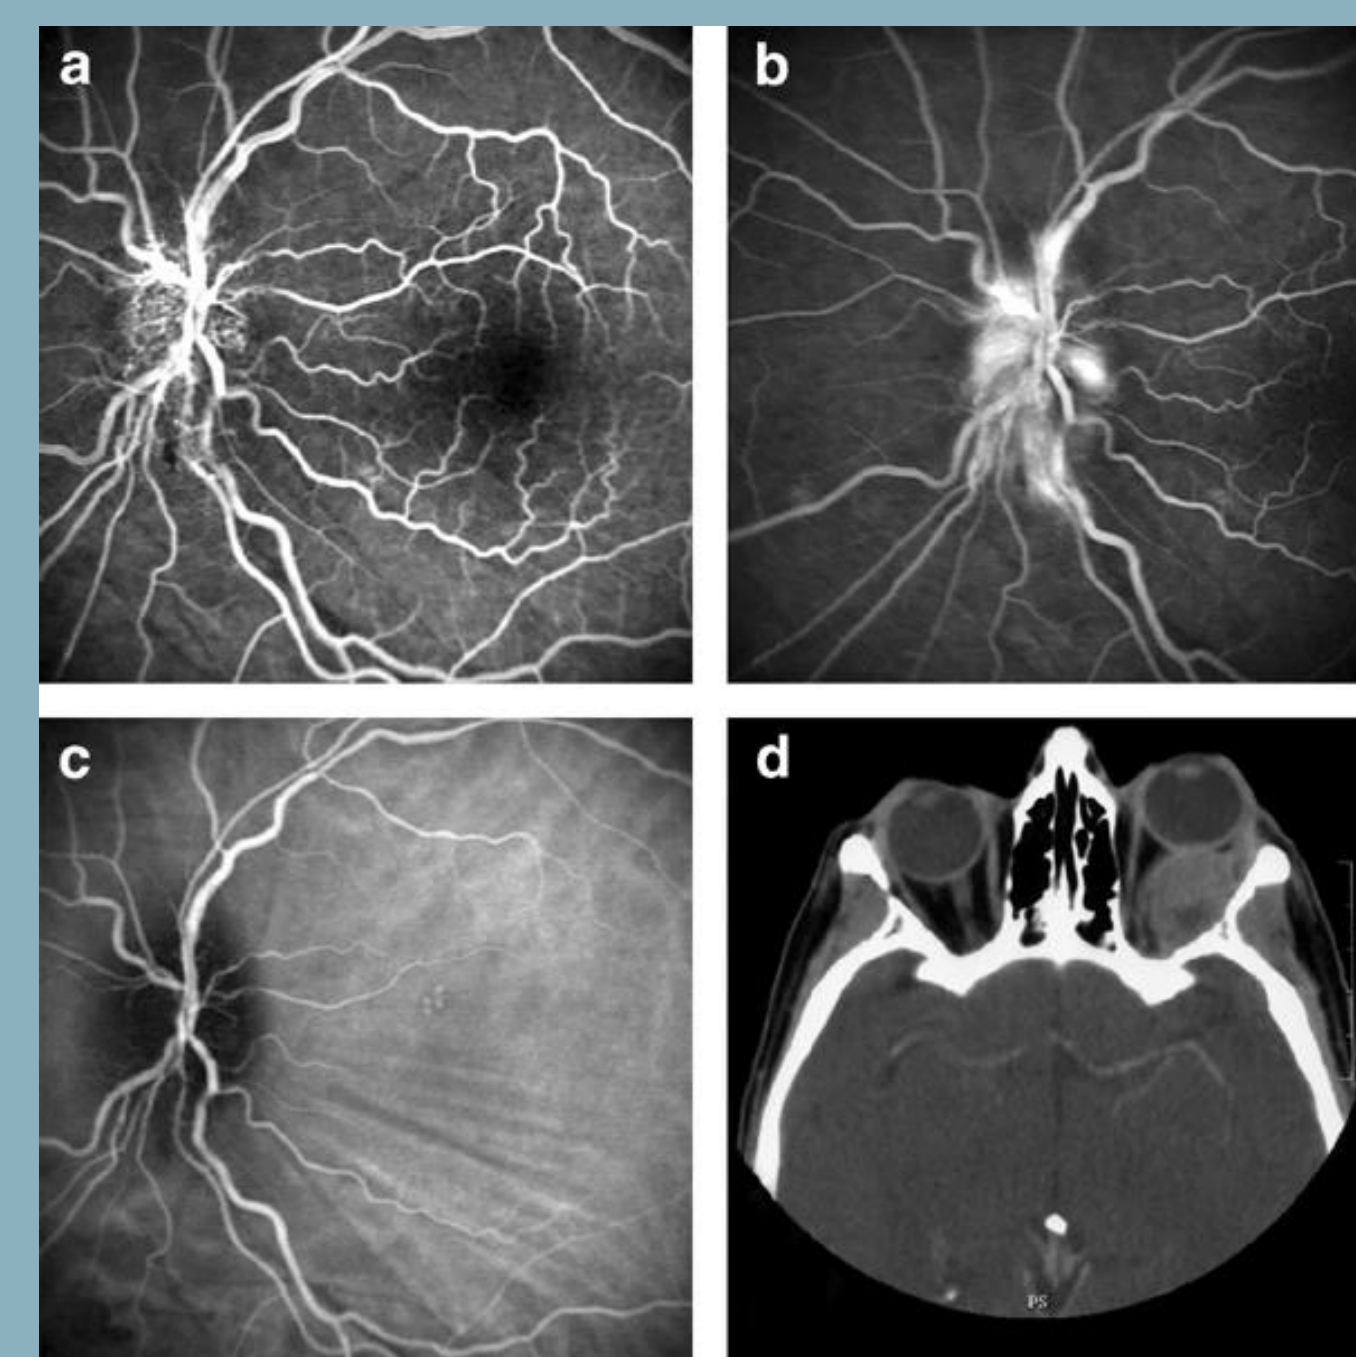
(a) Early fundus fluorescein angiography (FFA) showing swollen optic disc and choroidal folds. (b) Late fundus fluorescein angiography (FFA) showing optic disc swelling. (c) Indocyanine green angiography (ICG) showing swollen optic disc and choroidal folds. (d) Computerized tomography (CT) scan showing the orbital metastasis involving the left orbit
